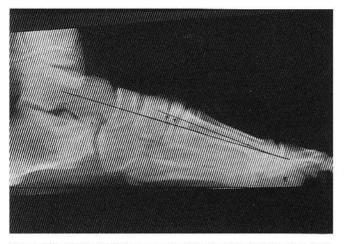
Supinated foot x-ray. The first metatarsal declination angle increases somewhat (E). The lateral talar first metatarsal angle increases in the negative direction as the talus dorsiflexes significantly (E).
